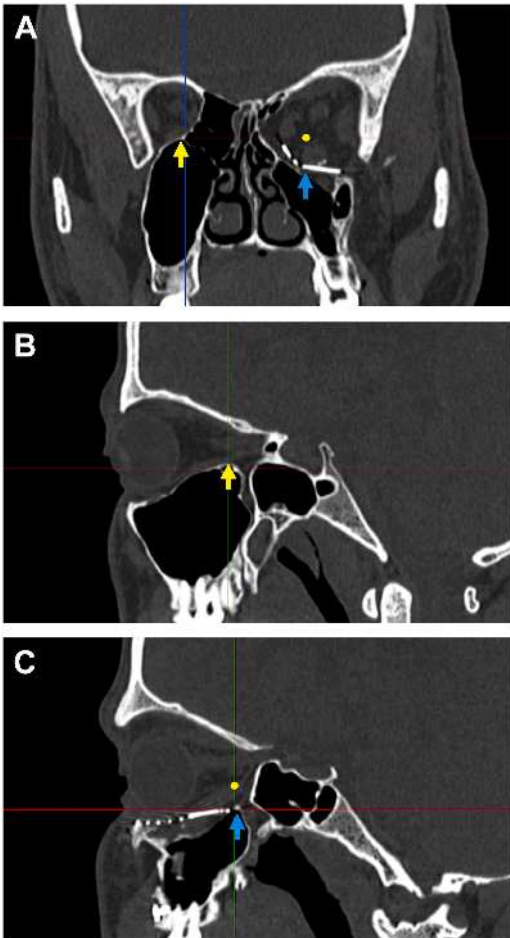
CT scan of a patient with left-sided orbital fracture demonstrating the absence of posterior ledge. (A) Coronal CT section with intact postero-medial bulge (yellow arrow) of the right orbit and a large fracture of the left. Yellow dot represents the ideal level of the posterior ledge as projected from the unaffected side. Blue arrow indicates inadequate earlier reconstruction and malposition of the implant. (B) Sagittal section of the same patient demonstrating intact (yellow arrow) postero-medial bulge of the right orbit. (C) Sagittal section of the left orbit demonstrates lack of posterior support for the implant with resultant suboptimal reconstruction.
